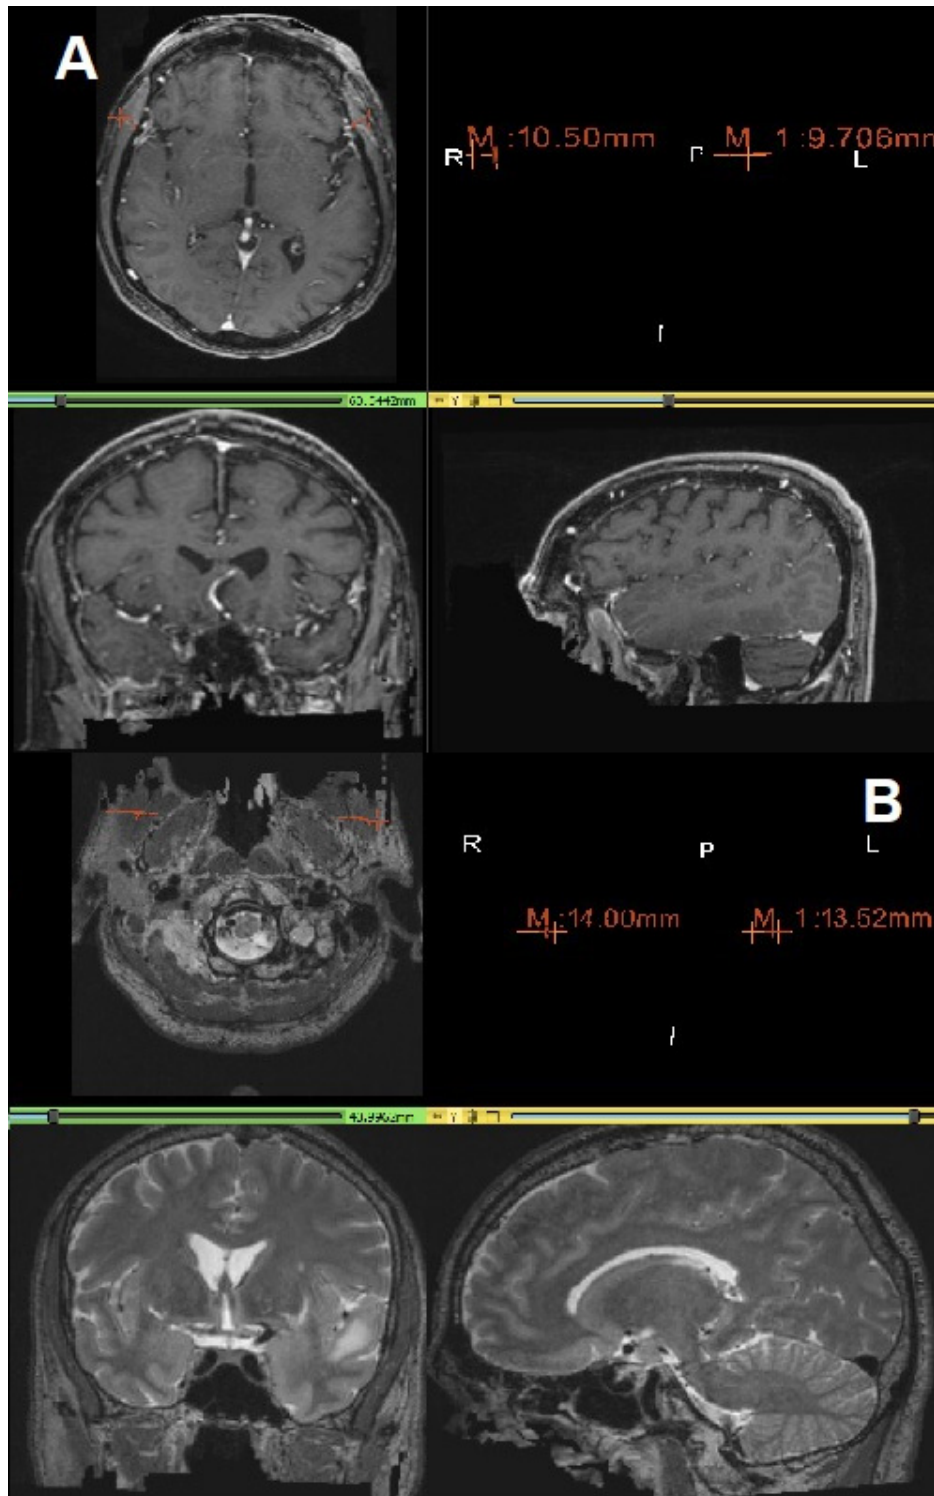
A) Contrast enhanced axial T1- weighted magnetic resonance images showing temporal muscle thickness (TMT) measurement. B) T2- weighted magnetic resonance images showing masseter muscle thickness (TMT) measurement.
